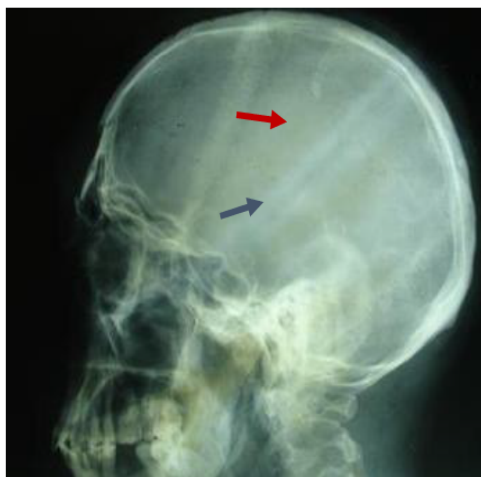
Standard radiograph of the skull in profile incidence showing a frontal fracture (→) and a fracture of the anterior wall of the frontal sinus (→)
